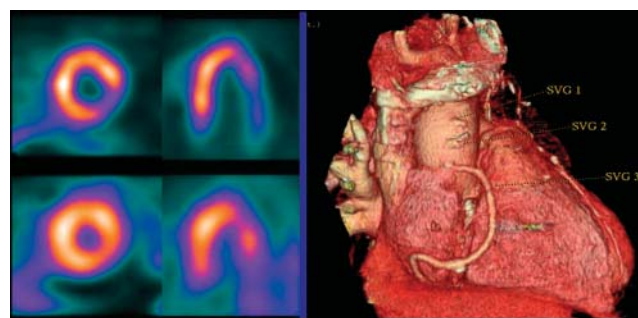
Left: Myocardial perfusion SPECT of lateral wall ischemia at stress (top) and rest (bottom). Right: CT angiography revealed multiple stenoses and occluded grafts.
